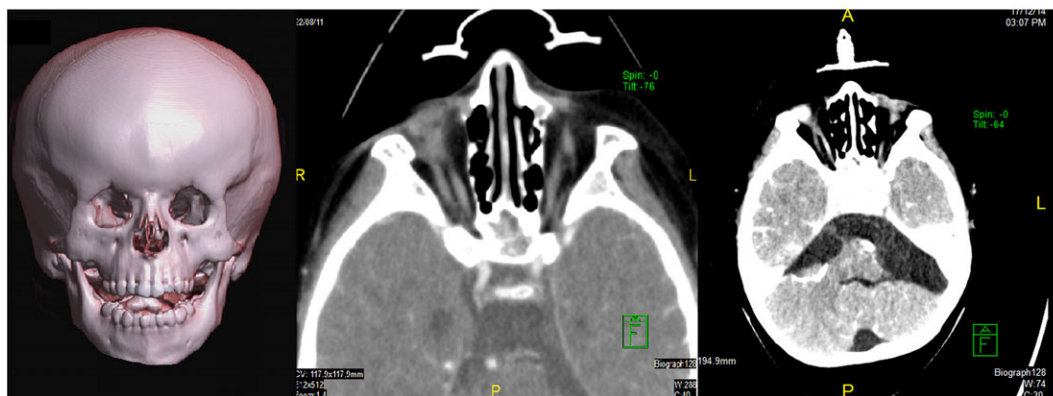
Brain computed tomography: (left) tridimensional reconstruction of the skull, (center and right) axial slices evidencing a lack of ocular globes with rudimentary extraocular muscles and optic nerves.
